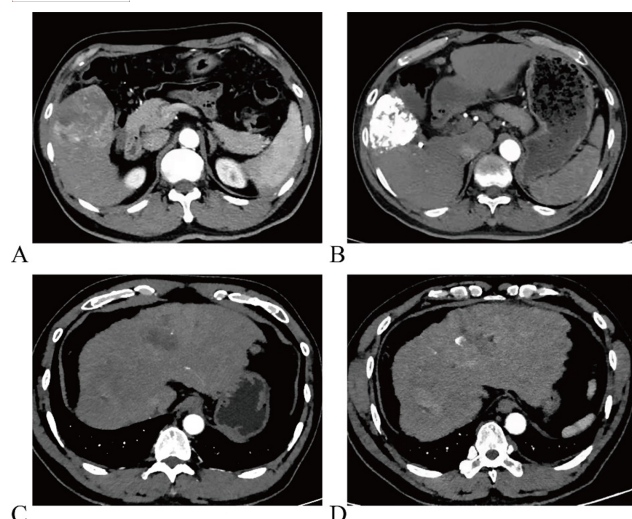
The efficacy evaluation by MRI imaging based on comparisons between before and after treatment. (A) The effective response before treatment (n = 30). (B) The effective response after treatment (n = 30). (C) The ineffective response before treatment (n = 30). (D) The ineffective response after treatment (n = 30). MRI, magnetic resonance imaging.
